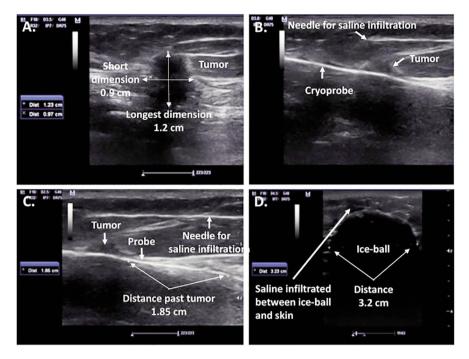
Ultrasound (US) guided cryosurgery for right breast invasive ductal carcinoma. (a) Size of tumour visualized by US. (b) Visualization of cryoprobe penetration and saline hydro-dissection. (c) Visualization of distance of probe and hydro-dissection needle projection past tumour. (d) The ice-ball, tumour, and safety freeze margin visualization (123).
